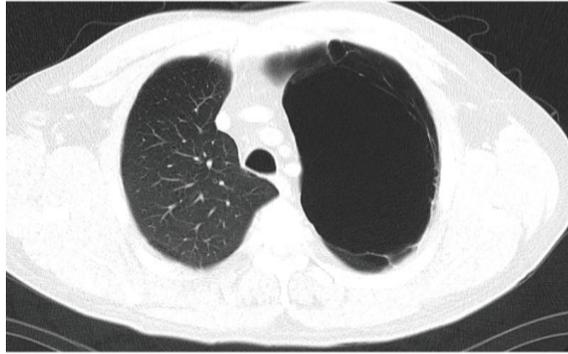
Computed tomography of chest that shows a parenchymal pulmonary destruction with a loss of alveolar attachments in left lobe of a patient with COPD. Adapted by Desai and Steiner [38].
